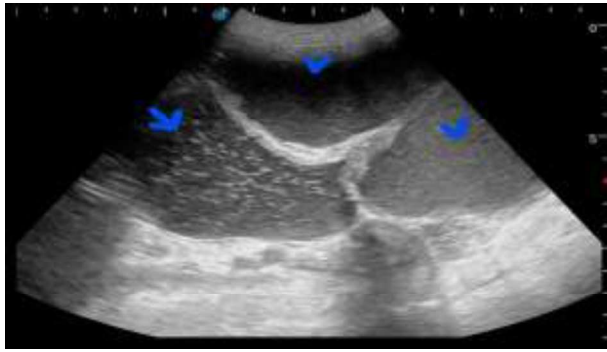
ultrasonographic view of the urinary bladder (arrow) and anechoic pockets within the prostate (arrowhead).
